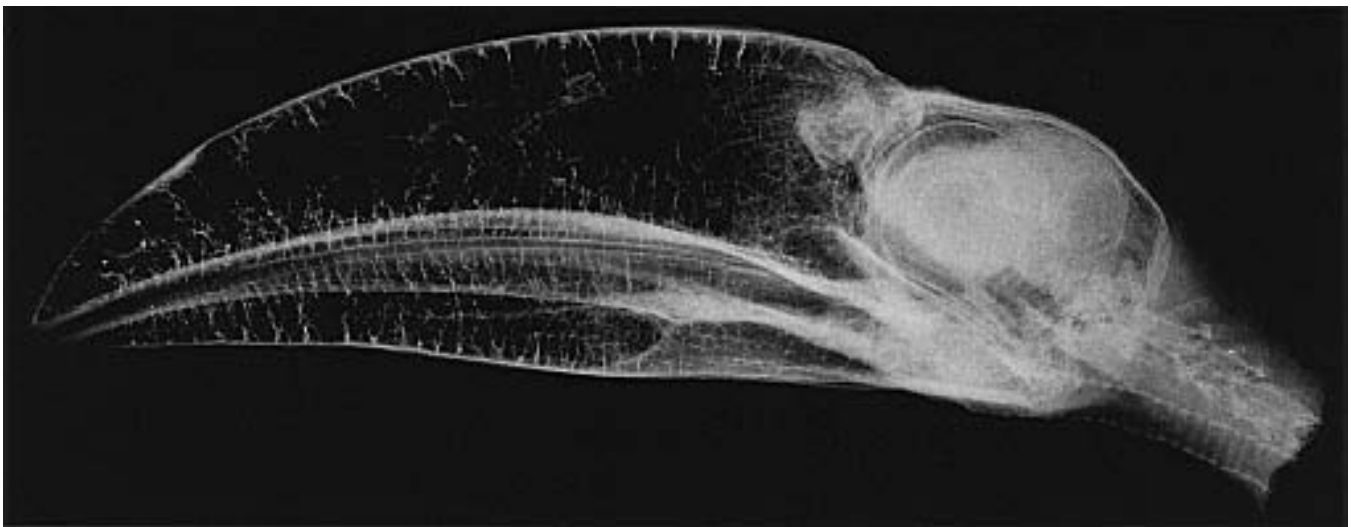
Radiograph of the head of a Channel-billed Toucan showing the massive bill composed of spongy bone. Note the large scleral ossicles that support the eyes (courtesy of Hans Cornelissen).
